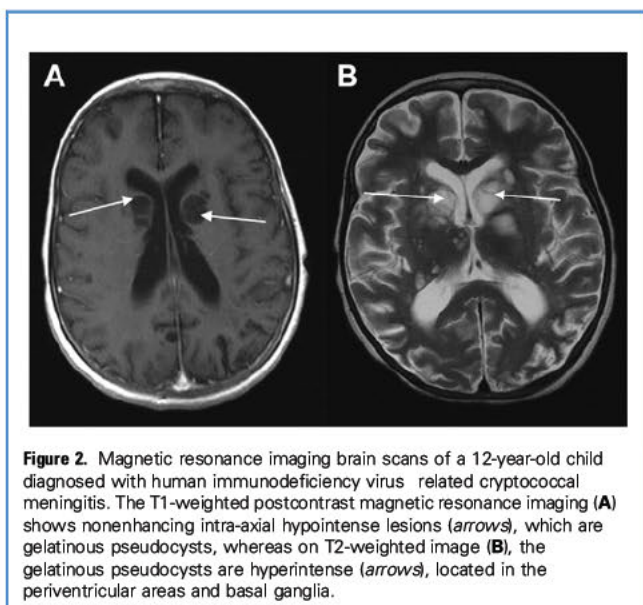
Magnetic resonance imaging brain scans of a 12-year-old child diagnosed with human immunodeficiency virus related cryptococcal meningitis. The T1-weighted postcontrast magnetic resonance imaging (A) shows nonenhancing intra-axial hypointense lesions (arrows), which are gelatinous pseudocysts, whereas on T2-weighted image (B), the gelatinous pseudocysts are hyperintense (arrows), located in the periventricular areas and basal ganglia.
